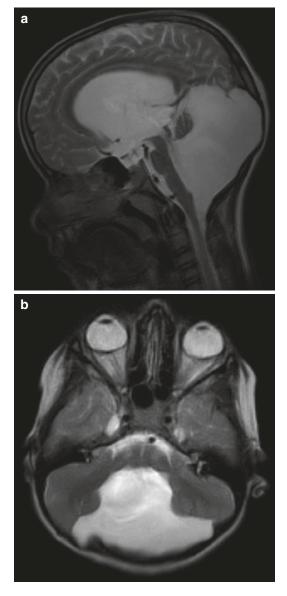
Dandy Walker Malformation (DWM). T2 W MR images in the midsagittal (a) and mid-fourth ventricle axial (b) plains show the salient features of the classic DWM namely the rotated and partially agenetic vermis, the high insertion of the torcular, the enlarged posterior fossa and the wide communication between the fourth ventricle proper and the 'cyst'. Note the widely patent aqueduct with flow void
